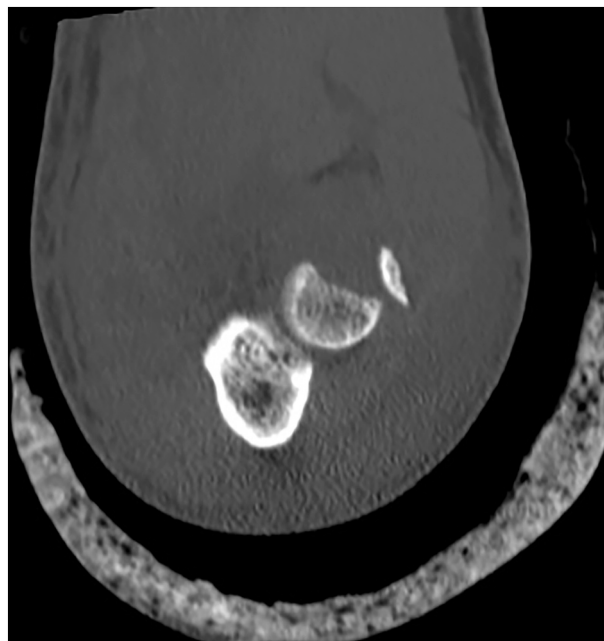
Computed tomography in a coronal section of the elbow with radial head fracture.
